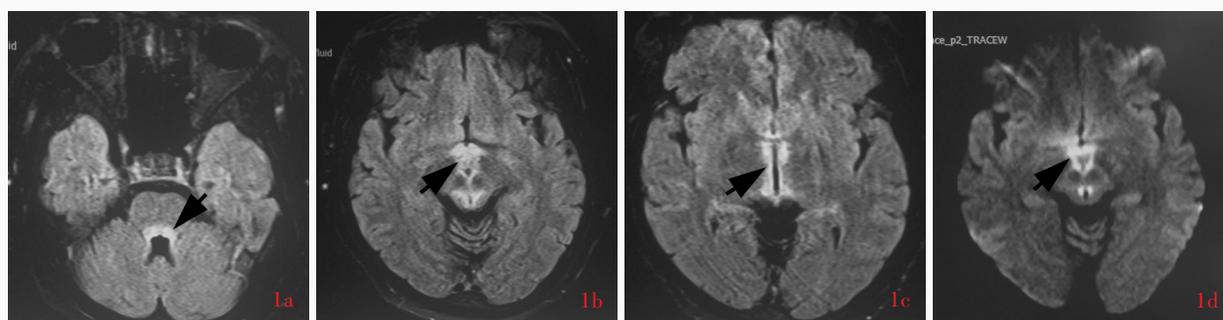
女性患者, 27岁, 因头晕、行走不稳7 d 并进行性加重, 嗜睡2 d 入院。既往有糖尿病病史, 近2个月减肥, 严格控制饮食摄入量(150 g/d)。体格检查双眼内收和外展功能不良, 左右视和上视可见眼震, 双侧跟-膝-胫试验欠稳准。临床诊断为 Wernicke 脑病。头部 MRI 检查所见 1a 横断面 FLAIR 成像显示, 第四脑室周围异常高信号影, 强度均匀(箭头所示) 1b 横断面 FLAIR 成像显示, 中脑导水管周围、四叠体、双侧乳头体和灰结节异常高信号影(箭头所示) 1c 横断面 FLAIR 成像显示, 第三脑室周围异常高信号影(箭头所示) 1d 横断面 DWI(图 1b 相同层面)显示, 病变呈明显高信号(箭头所示) 1e 通过乳头体的冠状位 T₁WI 显示, 第三脑室旁异常低信号影, 强度均匀(箭头所示); 双侧乳头体未见明显萎缩
